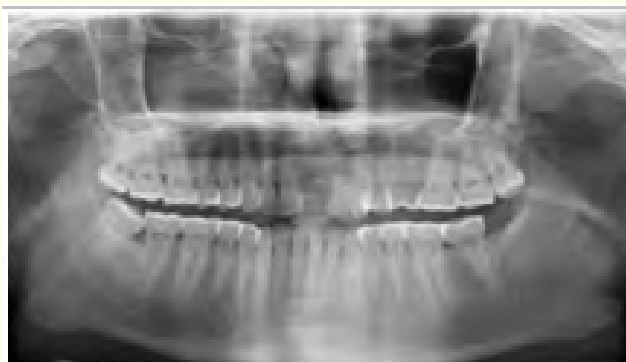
Pre-operative radiographic view.
